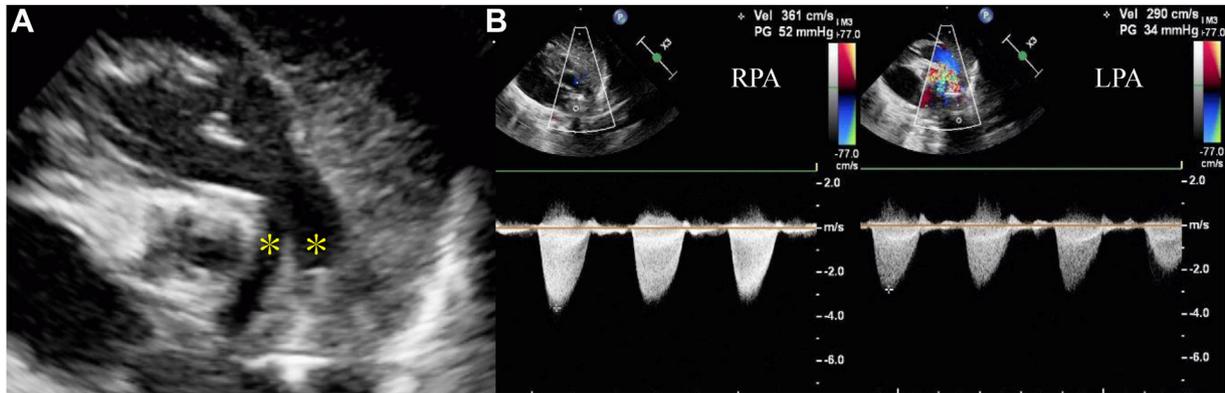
Two-dimensional TTE, parasternal short-axis view at the base, systolic phase, demonstrates (A) patent main pulmonary artery and luminal narrowing in the right and LPA branches (asterisks). (B) Color-guided continuous-wave spectral Doppler interrogation confirms high-velocity of 3.61 m/sec in the RPA (left panel) and 2.90 m/sec in the LPA (right panel) corresponding to peak gradients of 52 mm Hg and 34 mm Hg, respectively.
